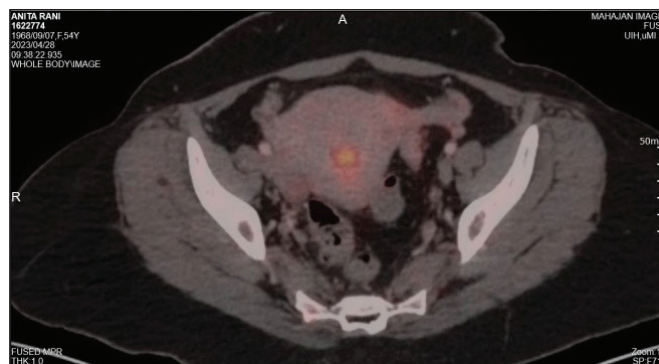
FDG avid hypodensity noted within the endometrial cavity
